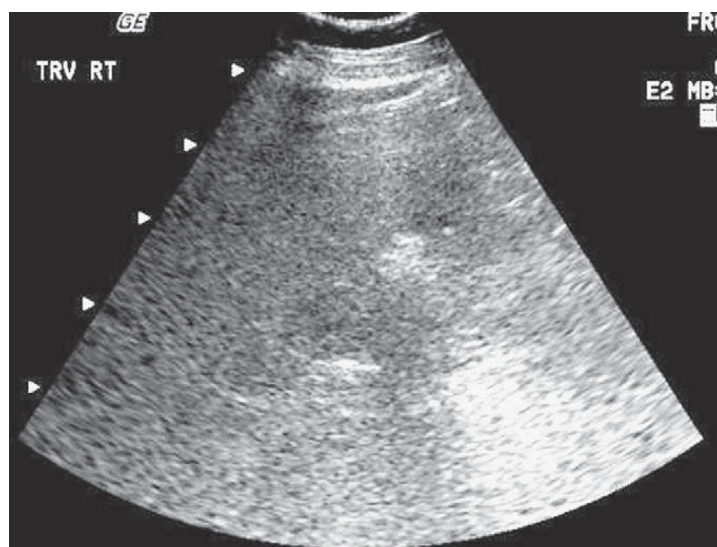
Ultrasound demonstrating increased echogenicity in a patient with NAFL.
